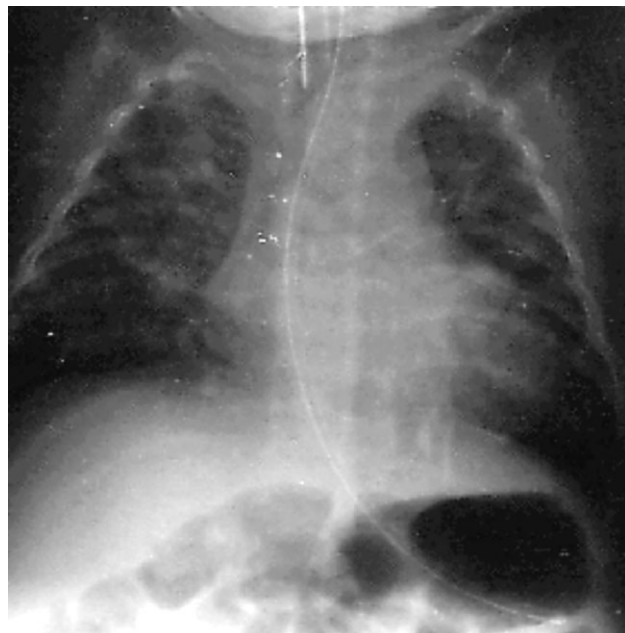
X-ray in the neonatal period.
